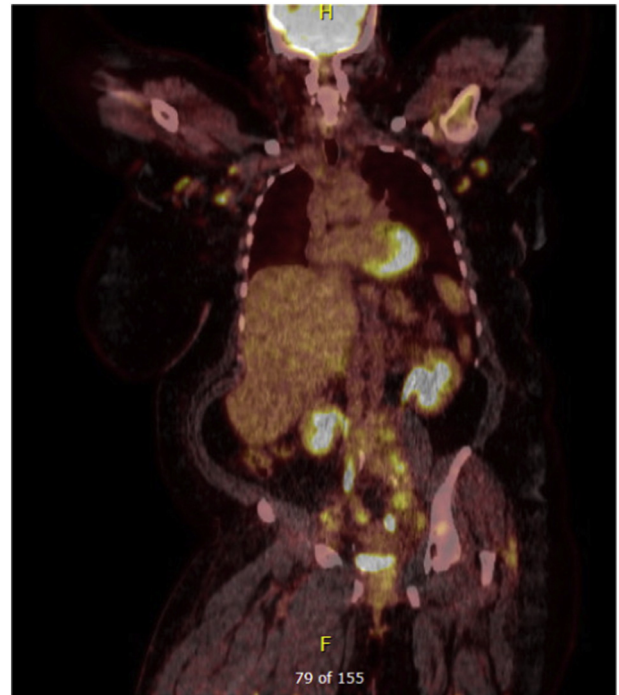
PET/CT demonstrating FDG avid cervical tumor and metastatic sites.
